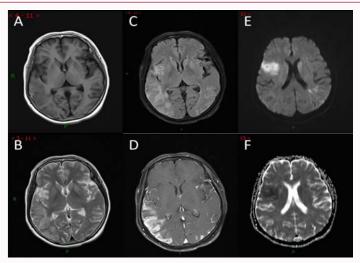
Brain magnetic resonance imaging and diffusion-weighted imaging on admission. (A-D) Brain magnetic resonance imaging on admission. (E, F) Diffusion-weighted imaging on admission.
